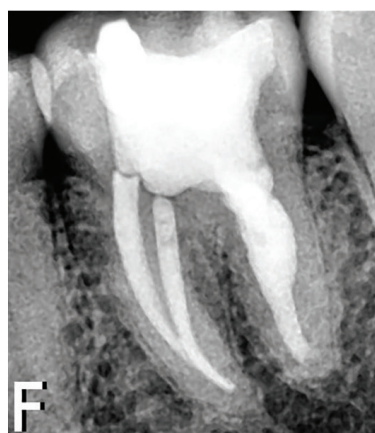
Immediate postoperative radiograph showing the obturated root canals. Note volume of the root canal filling material
